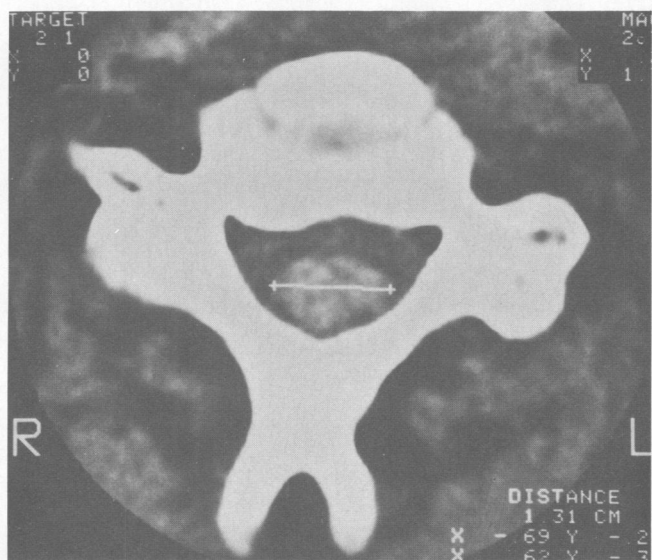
Case 1: A 6-hour delayed computed tomographic scan shows accumulation of metrizamide within the cord.
